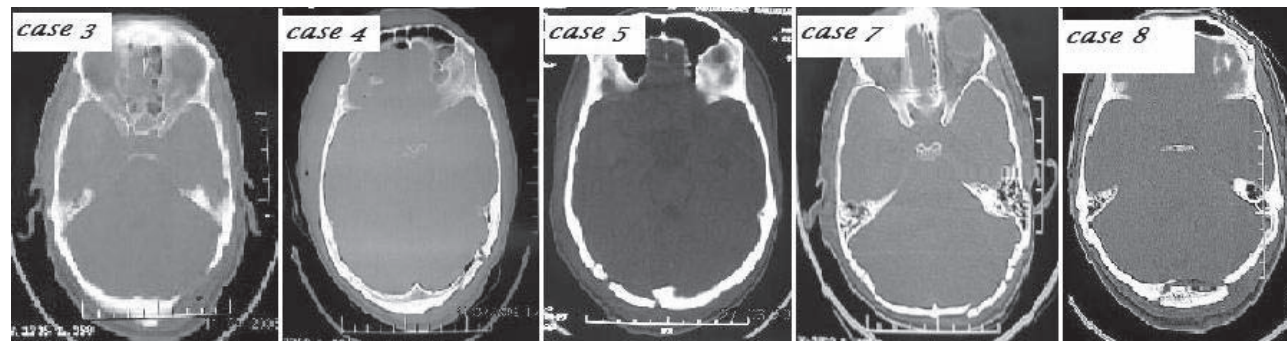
Post operative CT scans (bone window). Scans of C.No.1, 2 and 6 were not available.
